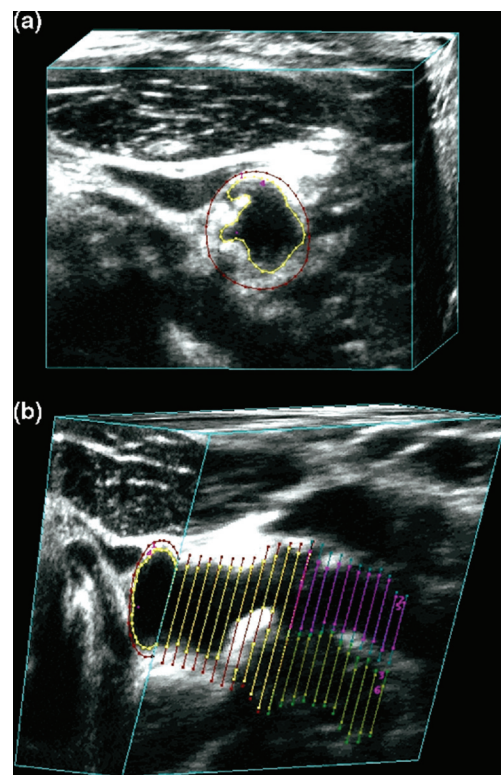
Vessel wall volume. Vessel wall volume segmentation. (a) The transverse view of the common carotid artery shows the vessel boundary outlined in red and the lumen boundary outlined in yellow. (b) The 3D ultrasound image volume is sliced longitudinally to reveal the vessel and lumen boundaries in the common, internal, and external carotid branches. The internal carotid artery vessel and lumen boundaries are shown in blue and pink, respectively. Reproduced by permission of Elsevier from: Egger M, Spence JD, Fenster A, Parraga G: Validation of 3d ultrasound vessel wall volume: an imaging phenotype of carotid atherosclerosis. *Ultrasound Med Biol* 2007, 33(6): 905–914.
